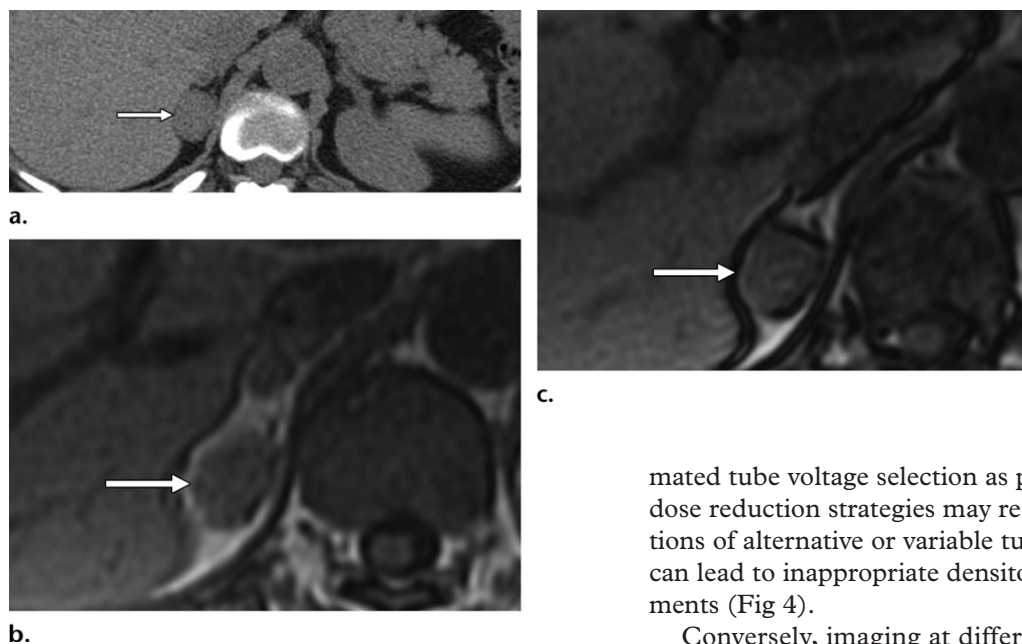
Evaluation of hyperattenuating nodules at nonenhanced CT. (a) Axial nonenhanced CT image shows an indeterminate right adrenal lesion (arrow), with a nonenhanced attenuation of 33 HU, suggesting a lipid-poor adrenal lesion. The patient erroneously underwent chemical shift MRI for further characterization. (b, c) Axial in-phase (b) and out-of-phase (c) chemical shift MR images show no signal loss, confirming the lesion (arrow) was not a lipid-rich adenoma. The lesion was indeterminate, and additional imaging with chemical shift MRI had not narrowed the differential diagnosis. Homogeneously attenuating lesions greater than 20–30 HU are unlikely to show lipid content at chemical shift MRI. Evaluation of enhancement kinetics with CT washout is more likely to help identify lipid-poor adrenal adenomas and is therefore preferable to chemical shift MRI.
